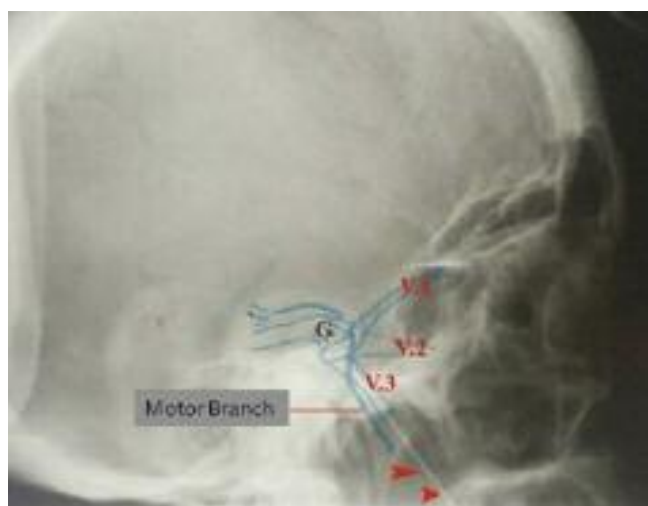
Lateral Skull X-ray incidence displaying position of radiofrequency probe (two red arrows), theoretical projection of trigeminal ganglion (G) and branches of trigeminal nerve (V1, V2, V3).
